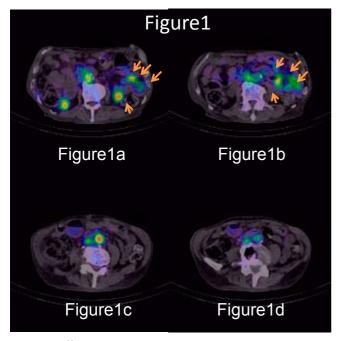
^{99m}Tc labeled human serum albumin scintigraphy showed high up-take of small intestine, indicating protein loss from small intestine (Figure1a-1b), and after discontinuing NSAIDs, the high up-take disappeared. (Figure 1c-1d).
